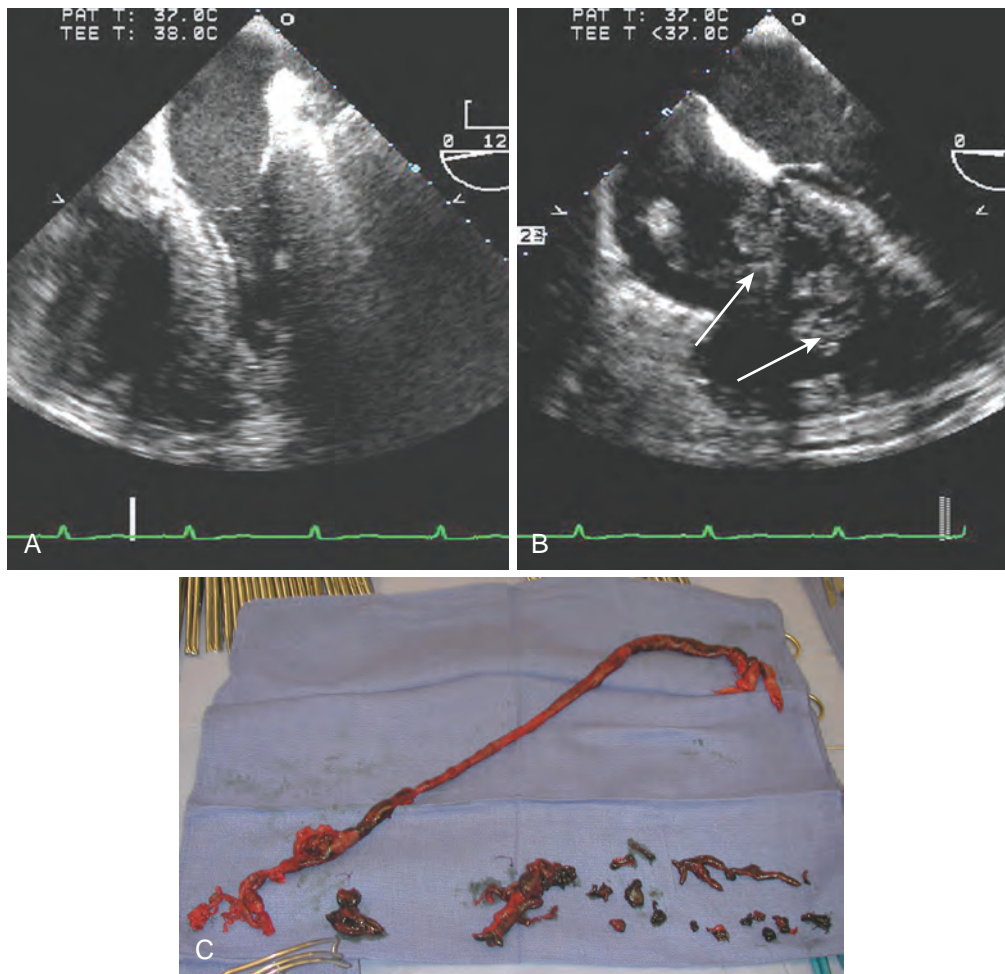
Progressive hypoxia and hypotension after cardiac surgery. A 58-year-old morbidly obese patient with a medical history of hypertension, diabetes, and smoking had recently undergone coronary artery bypass grafting $\times 3$. Five days after surgery, the patient experienced development of new-onset atrial fibrillation together with progressive hypoxia and hypotension requiring readmission to the intensive care unit. The patient's condition continued to deteriorate and required tracheal intubation, ventilator support, and infusions of vasoactive agents. Transesophageal echocardiography (TEE) was performed to evaluate cardiac function and rule out a pericardial effusion. (A) The midesophageal four-chamber view showed a dilated right ventricle (RV) coincident with a relatively underfilled left ventricle (LV) and abnormal positioning of the ventricular septum. The displacement of the septum into the LV was consistent with RV dysfunction and RV volume overload. (B) Inspection of the right heart revealed a dilated hypokinetic RV and a serpiginous density that extended from the right atrium into the RV. The thrombus appeared to be entangled in the chordal structure of the tricuspid valve. Although no thrombus was noted in the pulmonary arteries, the diagnosis of pulmonary embolism was made and the patient underwent an emergent embolectomy. (C) A right atriotomy was performed, and a 64-cm thrombus was extracted from the RV together with additional clots from both the right and left pulmonary arteries. The postbypass TEE documented improved right ventricular function and filling of the LV. TEE was critical in making the diagnosis and the decisions to institute and guide therapy.
